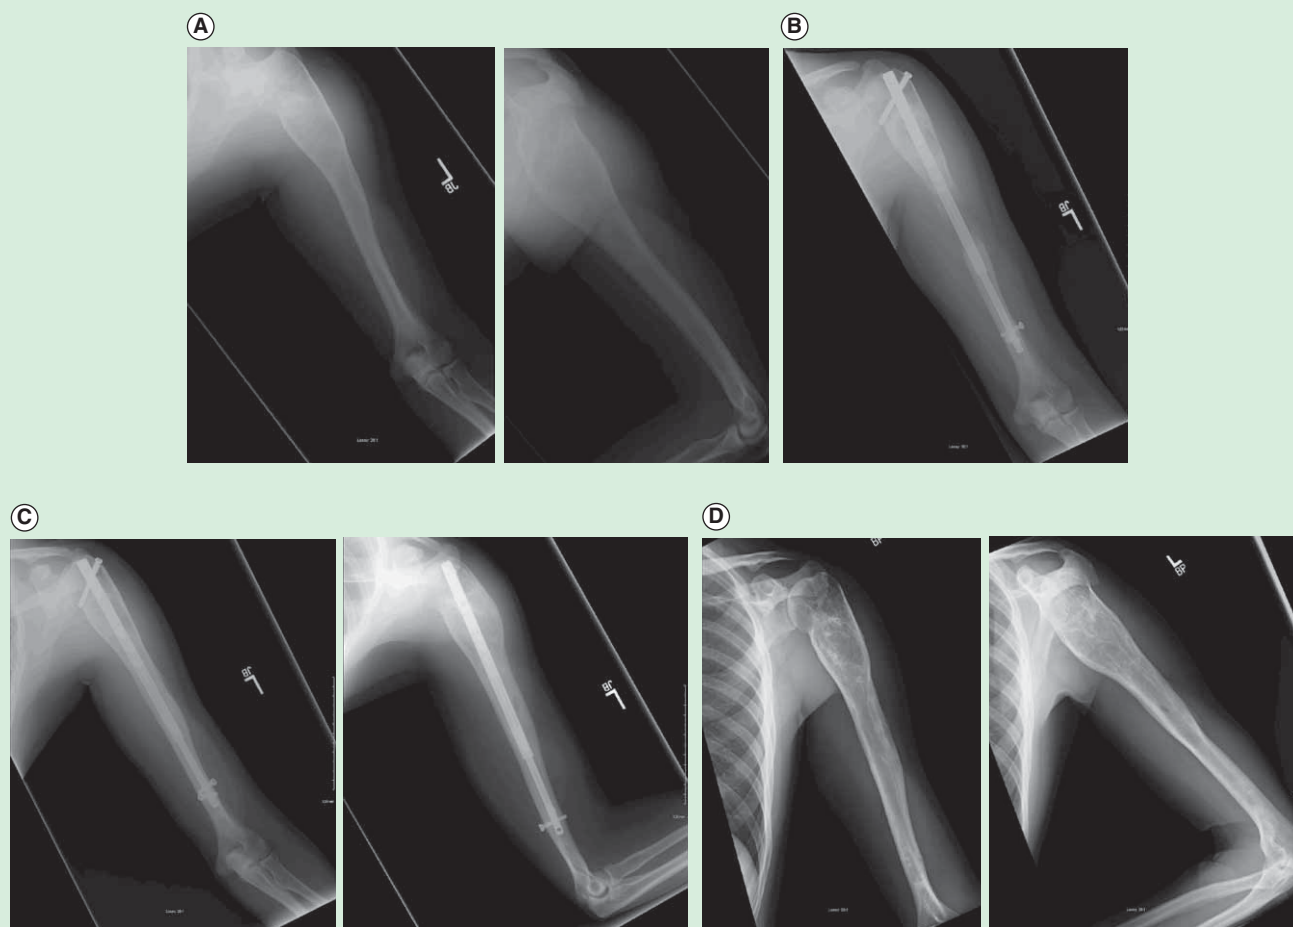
Arm shortening (6.5 cms) due to growth arrest from a unicameral bone cyst. (A) Preoperative AP and Lateral radiographs of left humerus (B) AP radiograph at the end of 6.5cms distraction using a 10.7mm Precice1 femoral piriformis entry nail. (C) AP and lateral radiographs after three months of consolidation. There is excellent bony bridging. (D) The nail was removed one year later. The bone and previous cyst are well consolidated.
